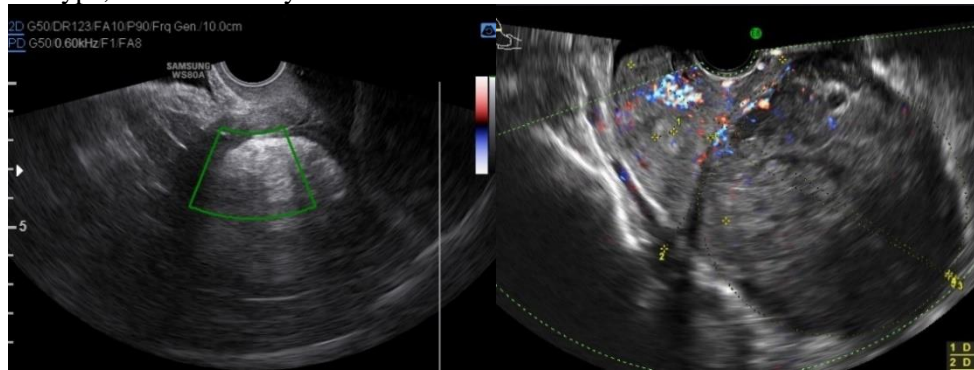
Transvaginal ultrasound images showing a hyperechogenic uterine lipoleiomyoma (A) and solid cellular leiomyoma (B). Transvaginal ultrasound shows in both cases uterine cervix (upper left corner) in a solid-cystic mass and solid lesion (B)
